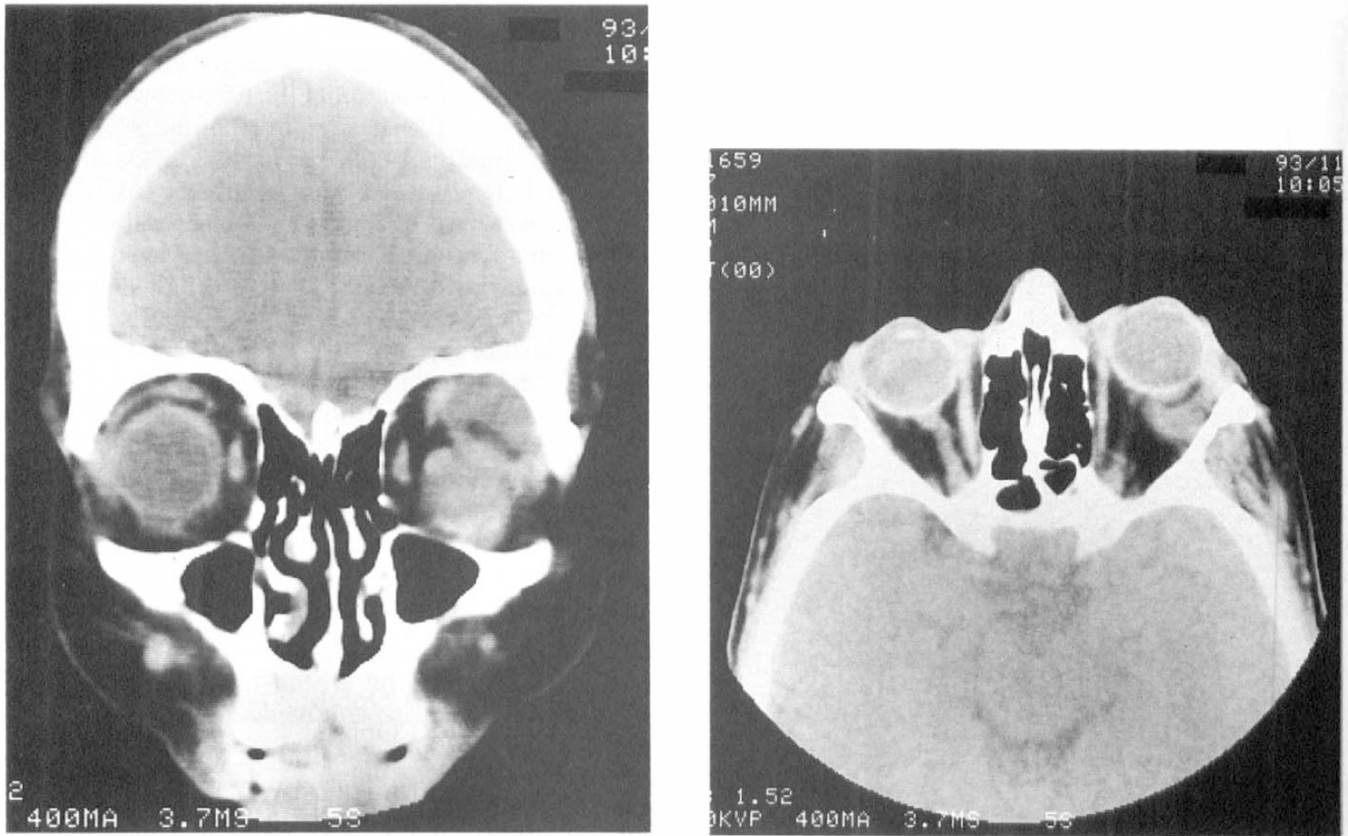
CT scans of the orbits showing the size and posterior extent of the encysted bleb. The radiolucent area within the bleb is the Molteno plate.
